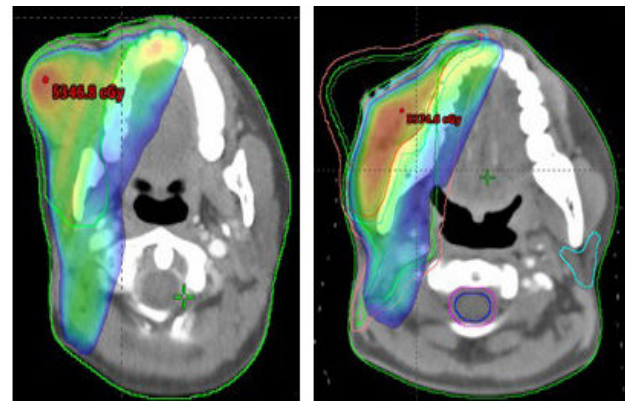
First and Repeat CT dose volume comparison.
